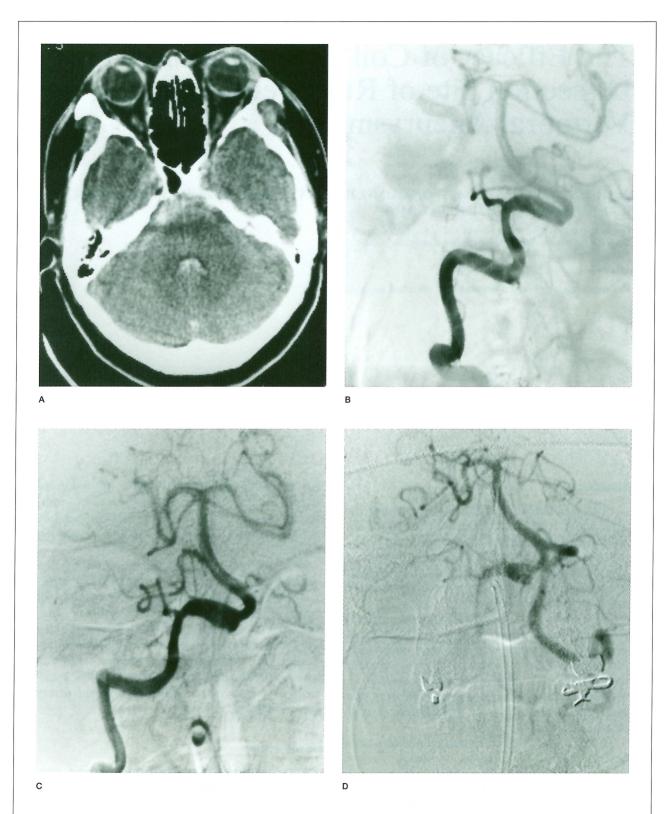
Case 1 A) Computed tomography showing a subarachnoid hemorrhage, located primarily in the pre-pontine cistern on the right side. B) Right vertebral angiogram on day 1, anteroposterior view, showing a dissecting aneurysm distal to the posterior inferior cerebellar artery origin. C) Follow-up right vertebral angiogram on day 16 showing progression of the dissection. D) Left vertebral angiogram after proximal balloon occlusion showing persistent blood flow to the right vertebral dissecting aneurysm.
